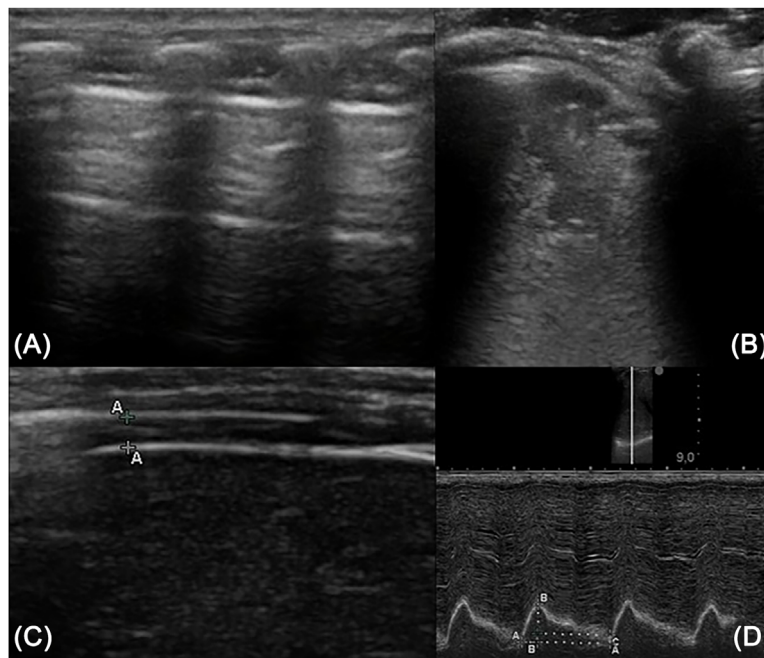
(A) normal chest ultrasound; (B) subpleural consolidation; (C) right emidiaphragm evidenced by the two hyperechoic lines; (D) diaphragm movement evaluated in M-mode: A-A all respiratory cycle, B-B diaphragm excursion, B-C expiratory phase, A-B inspiratory phase
